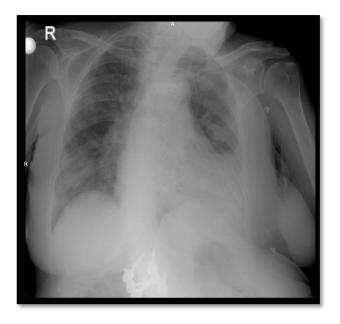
PA chest X-ray shows increased opacity in the middle-lower zone of the right lung and the middle-upper zone of the left lung after intro alveolar hemorrhage.
